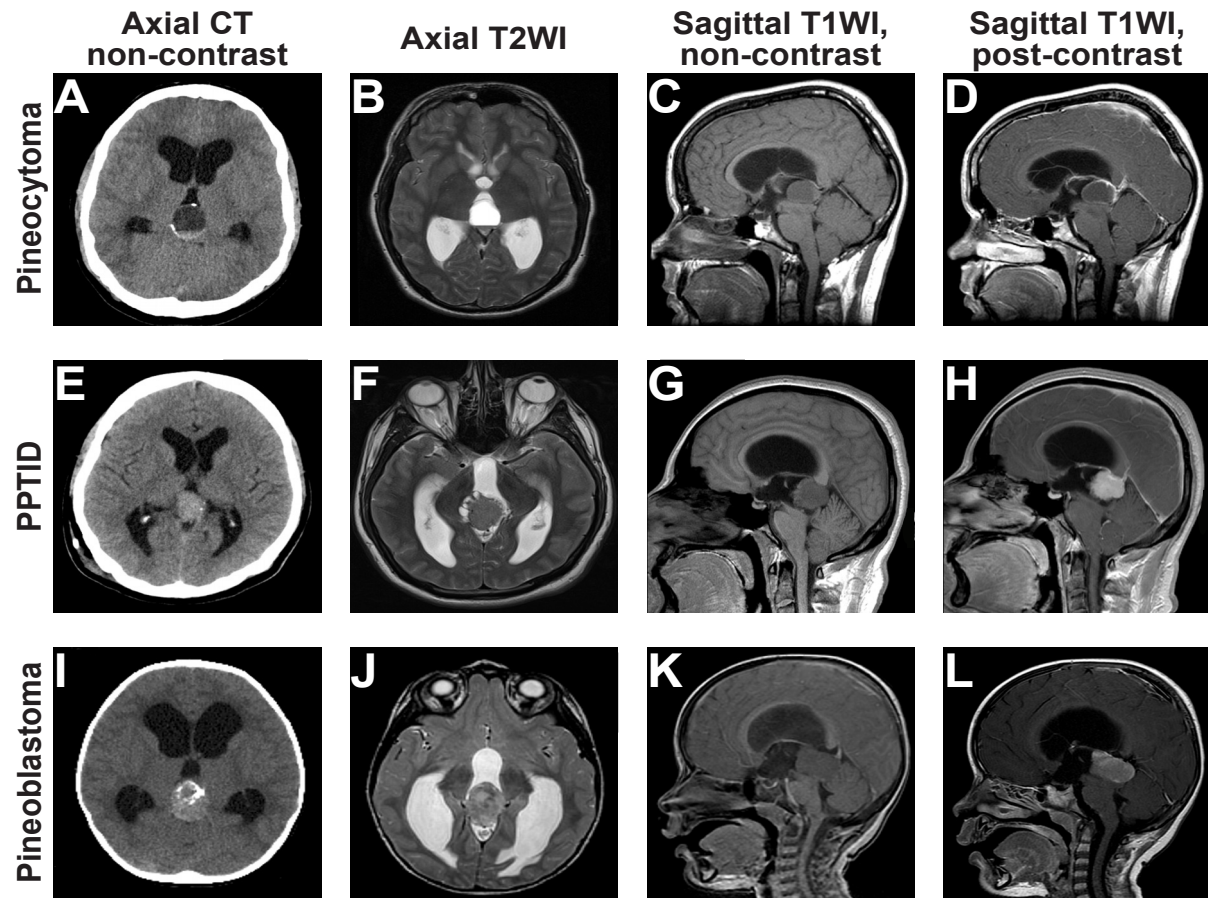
Radiographic characteristics of pineal parenchymal tumours. Computer tomography (CT) and magnetic resonance images (MRI) of pineocytoma (A–D), pineal parenchymal tumour of intermediate differentiation (PPTID, E–H), and pineoblastoma (I–L). Low-grade lesions are typically well circumscribed (C, D), while high-grade lesions may show evidence of local invasion (K, L). Although radiographic characteristics are non-specific for tumour grade, notable findings include cystic foci (B), peripheral “exploding” calcifications (I, E), and heterogeneous enhancement after injection of contrast (H, L).
